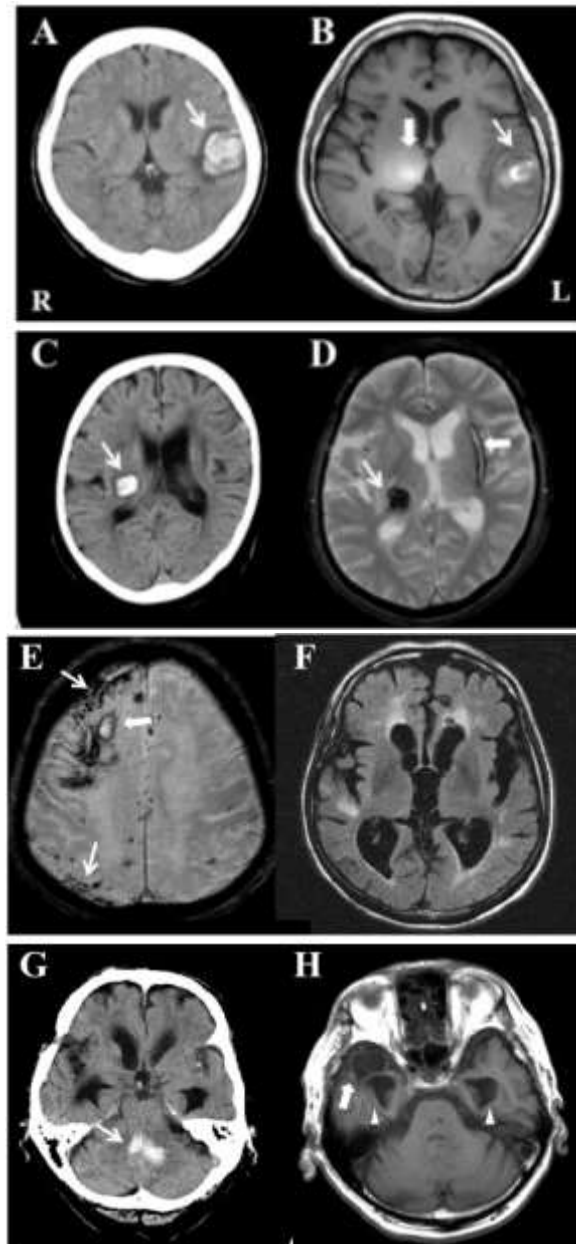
CT and MRI of the patients with intracerebral hemorrhage Case 1 (A, B); The arrows indicated subcortical hemorrhage (7.1 ml) in the left temporal lobe. The broad arrow was the artifact due to the coils. A, Brain CT, B; T1 weighted image, 1.5T, axial, TR; 525ms, TE; 12 ms . Case 2 (C, D); The arrows indicated the hemorrhage (2.2 ml) in the right putamen, and the broad arrow indicated the old hemorrhagic lesion of the left putamen. C, Brain CT, D; T2* weighted image, 1.5T, axial, TR; 660 ms, TE; 25 ms. Case 3 (E, F); Broad arrow indicated subcortical hemorrhage in the right frontal lobe. Many micro bleeds were showed, and some (arrows) were clustered. Brain atrophy with ventricular dilatation and periventricular high signals were also elucidated. E; T2* weighted image, 1.5T, axial, TR; 814 ms, TE; 24.6 ms. F; T2 weighted image, 1.5T, axial, TR; 10000 ms, TE; 120 ms. Case 4 (G, H); The hemorrhage (arrow) in the deep part of cerebellar hemisphere, the old infarct (broad arrow) in the polar head of right temporal lobe and the ventricular dilatation (arrow heads) were shown. G; Brain CT, H; T1 weighted image, 1.5T, axial, TR; 530 ms, TE; 12 ms.
